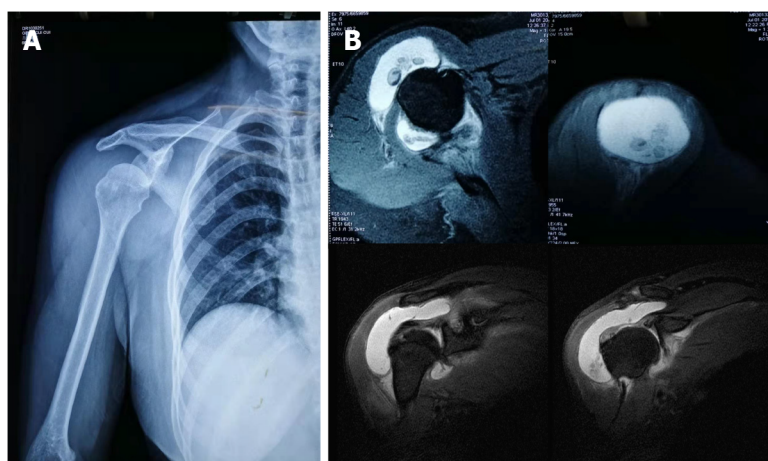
Imaging examinations of case one. A: Plain radiograph in anteroposterior view of the right shoulder, showing subluxation of the humeral head; B: Magnetic resonance imaging examination of the shoulder joint, showing multiple intra-articular loose bodies and joint effusion.
